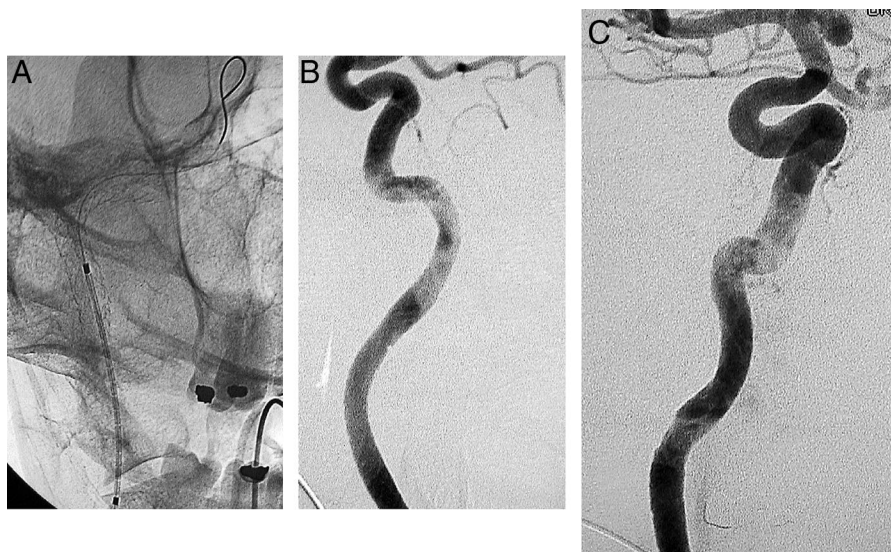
(A) Plain X-ray showing a phase of the insertion of the stent in the C1 segment after a stent in the C2 segment has already been deployed. Notice partial overlapping of the stents. Lateral (B) and oblique (C) angiographic views of the internal carotid artery after stenting showing resolution of the stenosis.
